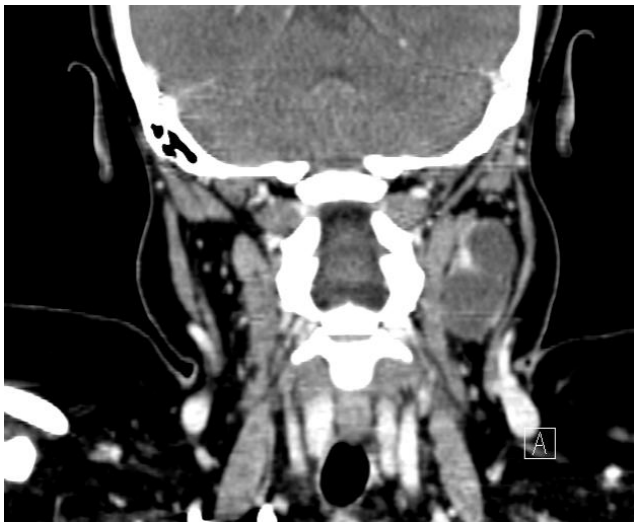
b: Coronal CT scan of the neck with contrast showed cystic mass with multiple reactive lymph nodes
